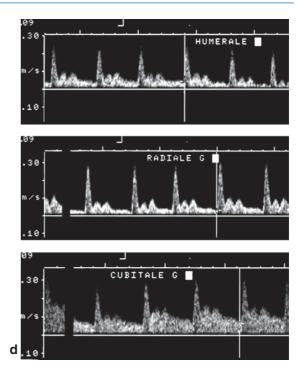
(*cont.*) Twenty-four hours after antegrade FIN, radial pulse was absent and capillary pulse was slow. Angiography showed occlusion of the brachial artery (\mathbf{b}, \mathbf{c}). A venous bypass was performed, and 1 year later, Doppler echography confirmed graft patency (\mathbf{d})
